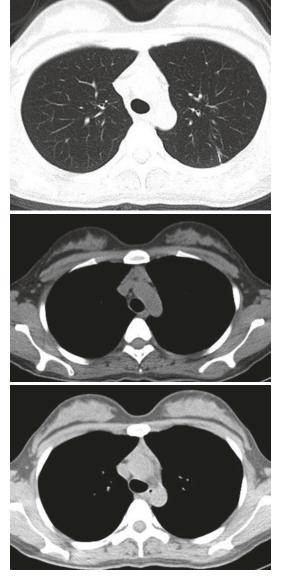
Chest CT: airway clearly shown in routine lung window, mediastinal window, and mediastinal-fat window
